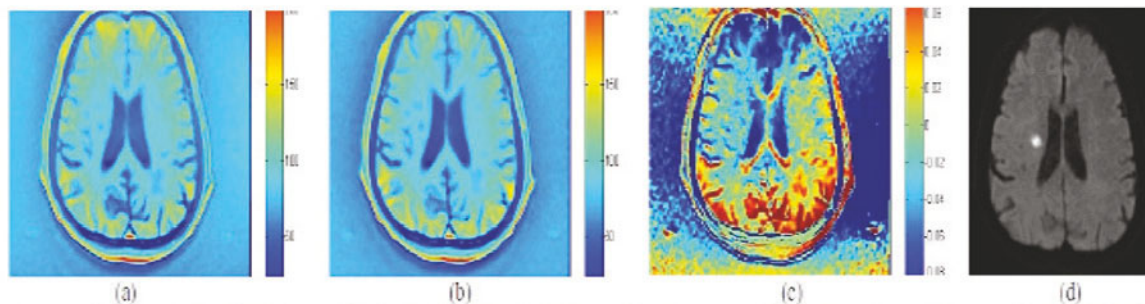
Representative MR images of a brain infarction at 1.5T: saturated image at 224Hz (a), saturated image at -224Hz (b), the APT image(c), the DWI image(d).
